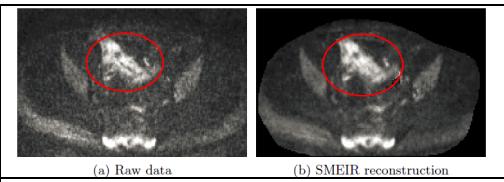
Representative Crohn's disease patient with active inflammation in the ileum. (a) The acquired raw DW-MRI data; and (b) SMEIR-reconstructed data. The region with active inflammation is more conspicuous in the SMEIR-reconstructed image.
